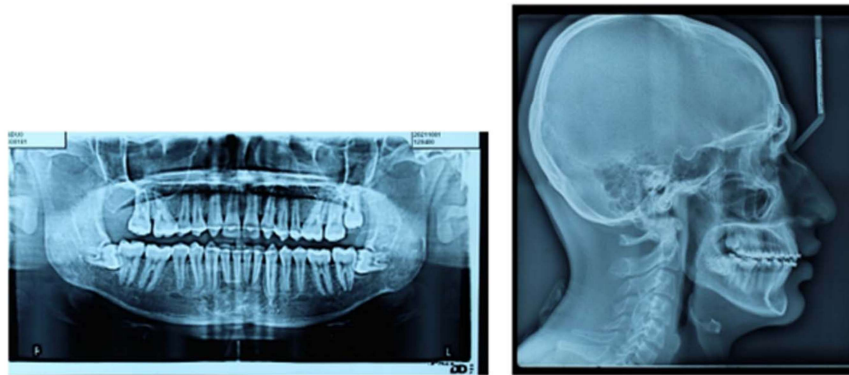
Radiographs after treatment
